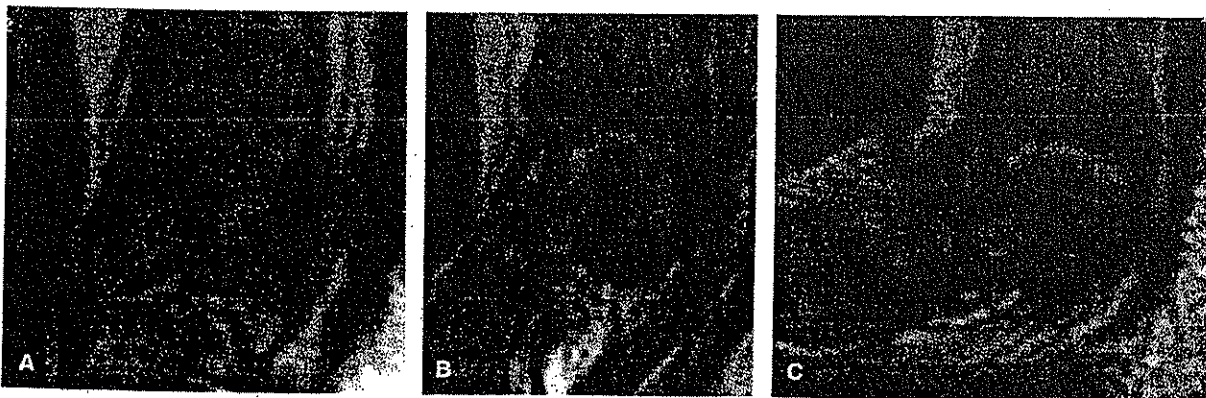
Patient 1. Sequential sagittal magnetic resonance images perpendicular to the bimalleolar axis show progressive correction of tibiotalar plantarflexion and inferior talonavicular subluxation from the first cast (A) to the third cast (B) to the fifth cast applied after percutaneous tenotomy (C).
